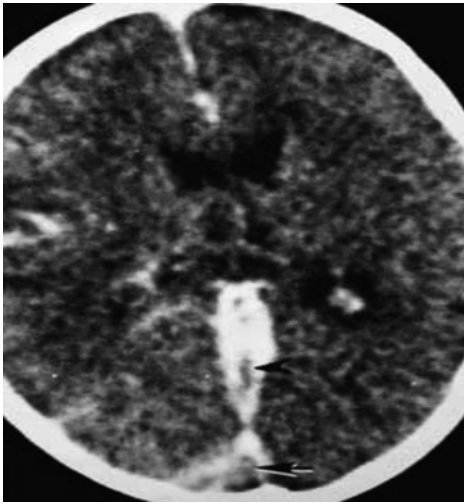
Axial head CT scan demonstrating cerebrovenous thrombosis of the straight sinus (*arrowhead*) and the empty delta sign (*arrow*)
